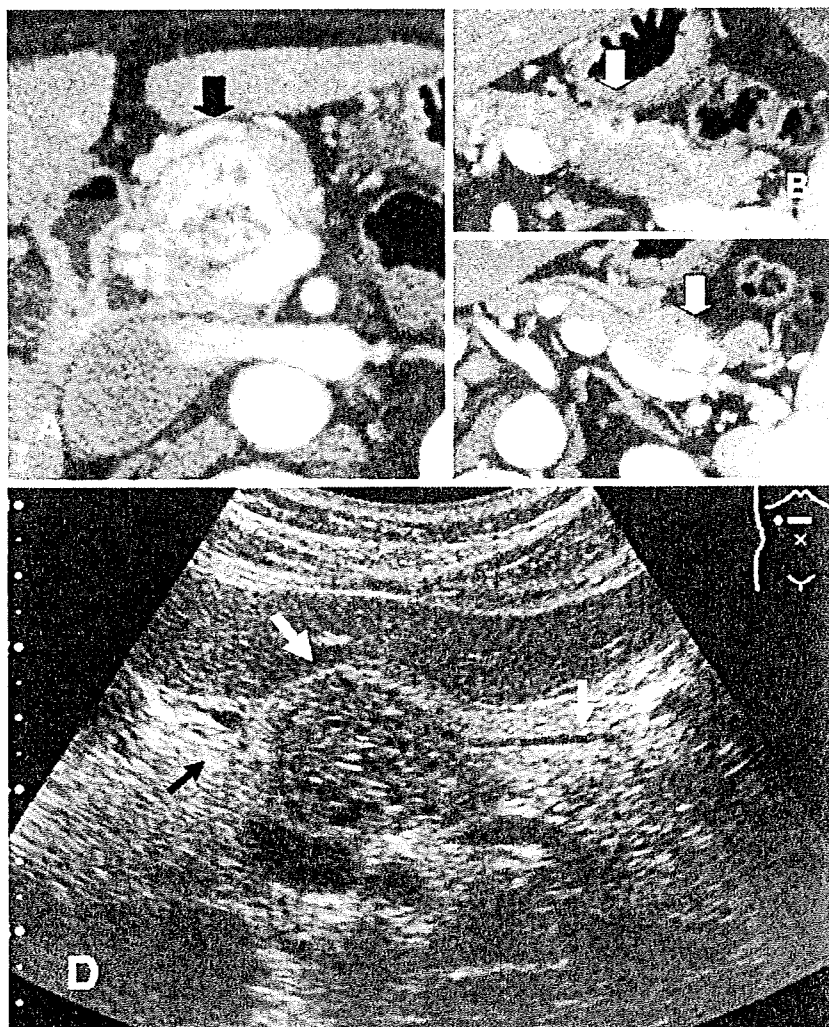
Multidetector-row computed tomography (MDCT) showed A a 30-mm hypervascular tumor in the pancreatic neck (T1; *black arrow*); B a 7-mm tumor in the pancreatic tail (T2; *white arrow*); and C a 10-mm hypervascular tumor in the pancreatic tail (T3; *white arrow*). D Abdominal ultrasonography showed a round and heterogeneous echoic mass, 30 mm in diameter, with slight dilation of the main pancreatic duct (*white arrows*); the *black arrow* indicates the gastroduodenal artery
